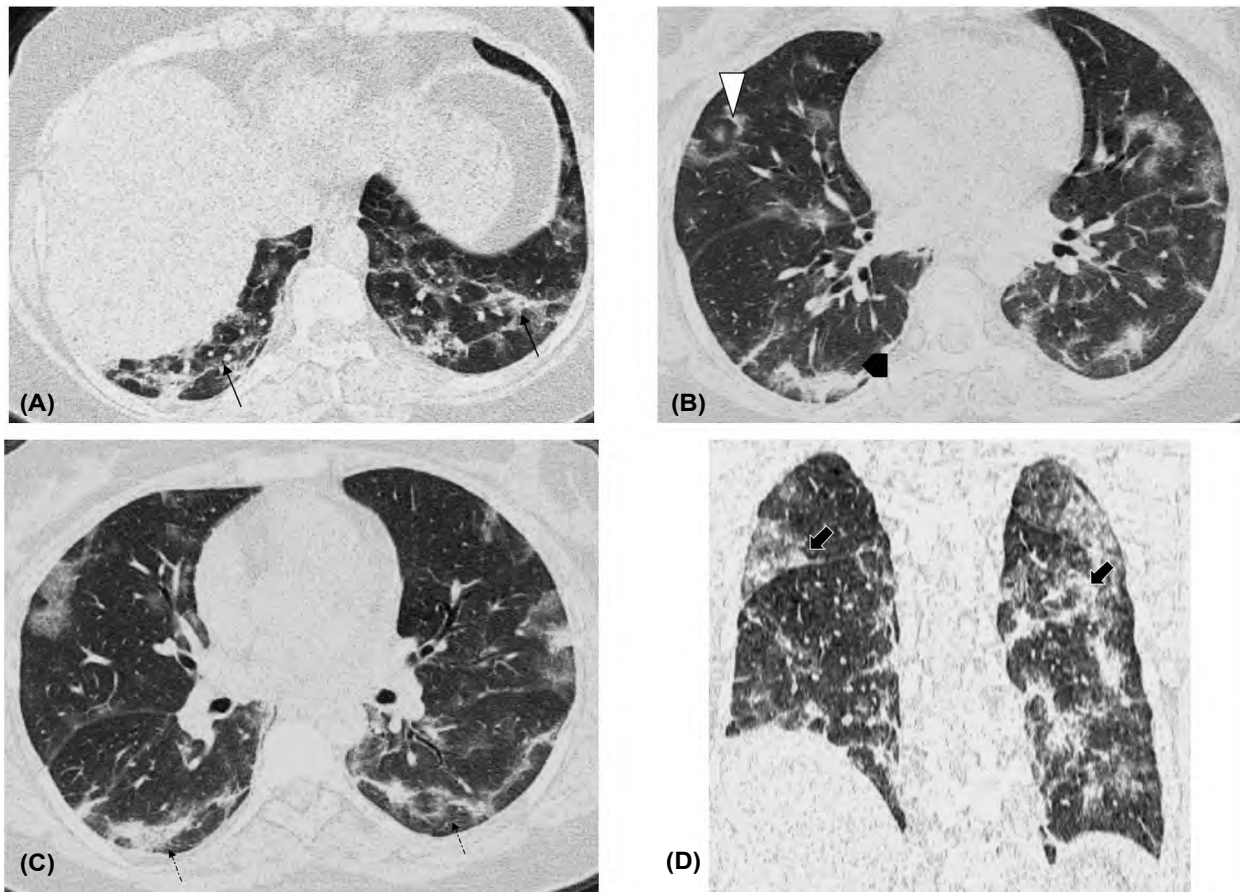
48 year-old Female patient, presented with mild symptoms of COVID-19 pneumonia. Her Chest CT findings were coping with CO-RADS 5 category and CT score was 8. The patient was admitted to isolation ward and discharged after 14 days with no need for supportive ventilation. Non contrast CT chest: A. Axial image shows bilateral lower lobe subpleural GGO with atelectatic bands (thin black solid arrows). B. Axial CT image shows right middle lobe halo sign (white arrowhead) and right lower lobe consolidation opacifications (thick black arrow). C. Axial CT image shows bilateral lower lobe subpleural GGO (thin black dashed arrows). D. CT images with coronal reconstruction show bilateral GGO with lower lobes and peripheral predominance (thick black arrow).
